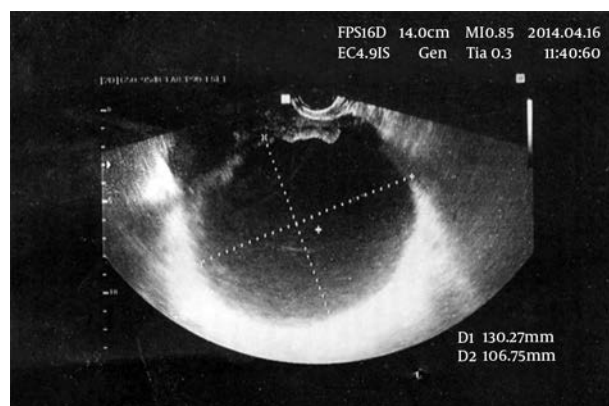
Sonography View of the Large Complex Cyst in the Ovary
